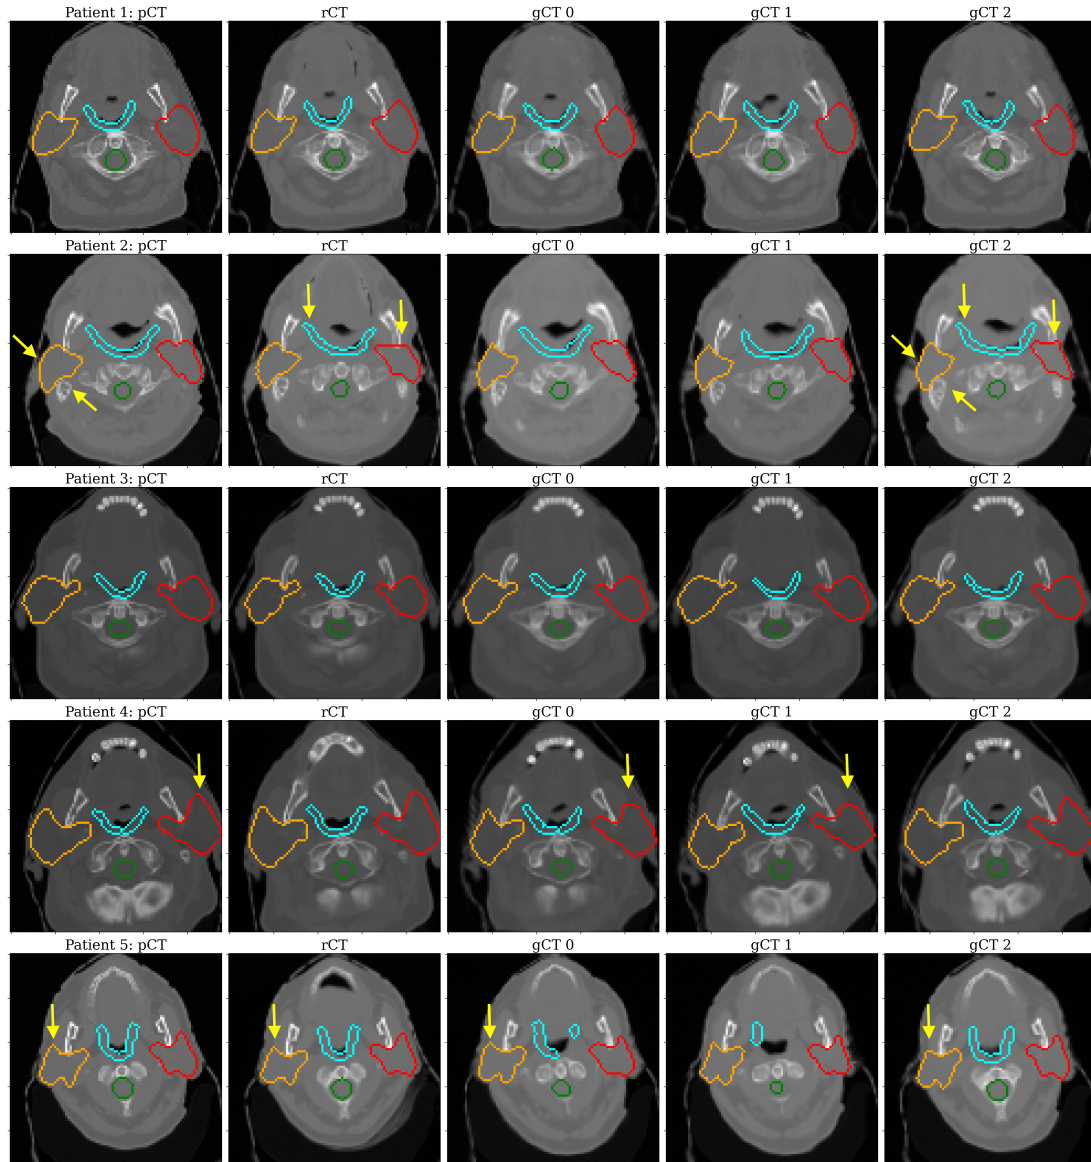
Example of generated images. The figure displays, for 5 randomly selected patients from the test set, in the first column the true pCT, in the second column one of the true rCTs and in the remaining columns generated CT images. Overlaid on all images are the left parotid (red), the right parotid (orange), the spinal cord (green) and the constrictor muscle (blue). Noteworthy anatomical changes are indicated with yellow arrows.
